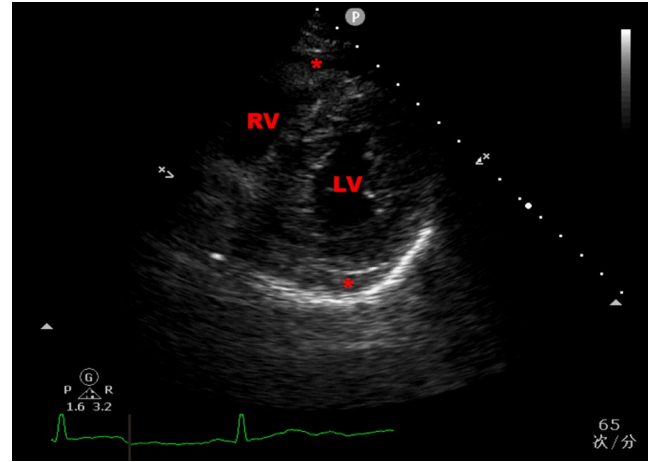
Thickened left ventricular wall and small pericardial effusion in a patient with COVID-19. Legend: Using RC-B-TTE, thickened intraventricular septum and left ventricular wall and small pericardial effusion* were found in a critical COVID-19 patient, which had been missed by the frontline echocardiographer. Abbreviations as in Figures 1 and 2
